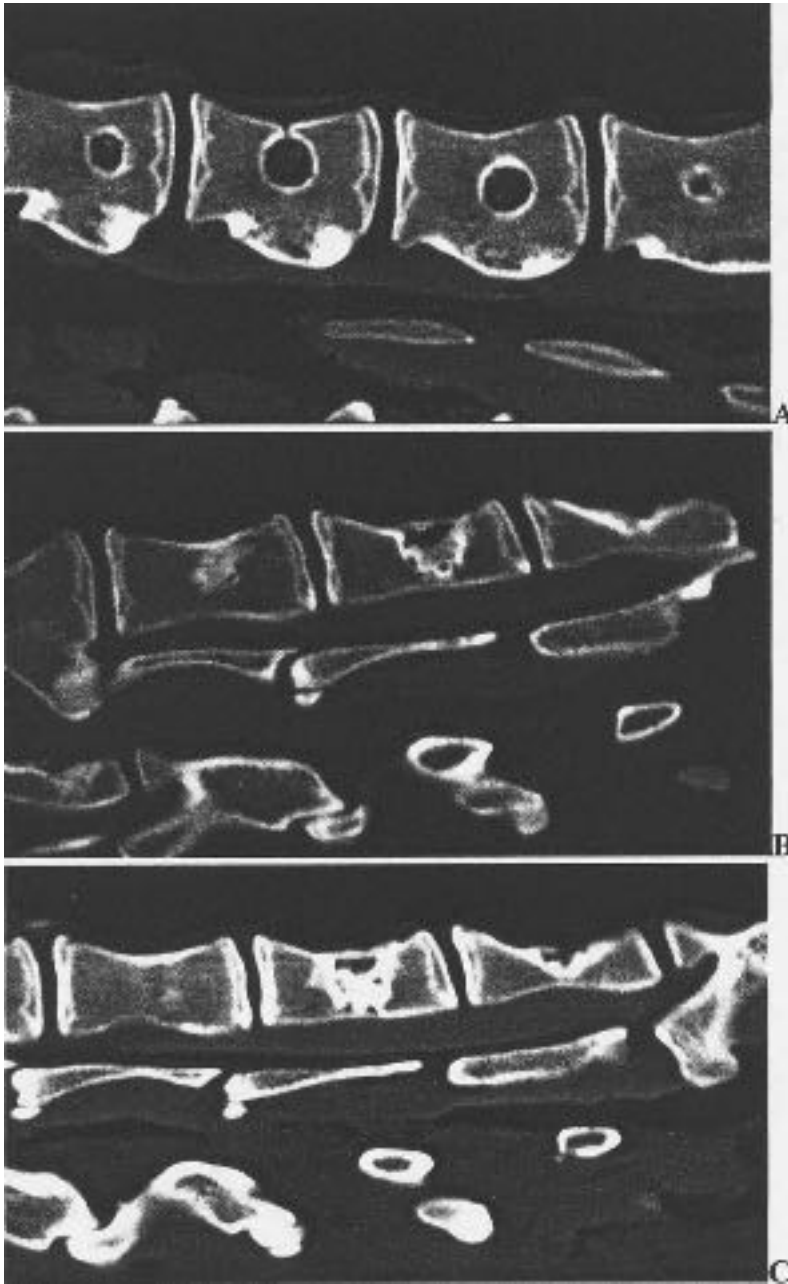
Computed tomography of lumbar spines with 10 mm defects at three months. (A) Defects initially left empty remained poorly filled. The implants of (B) autogenous bone and (C) POP showed a similar pattern of healing.
